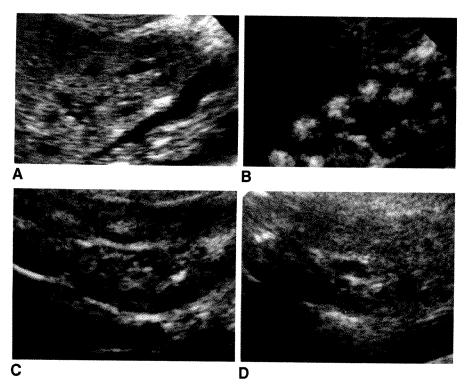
A, Renal sonogram of 3-day-old neonate shows normal echogenicity.
